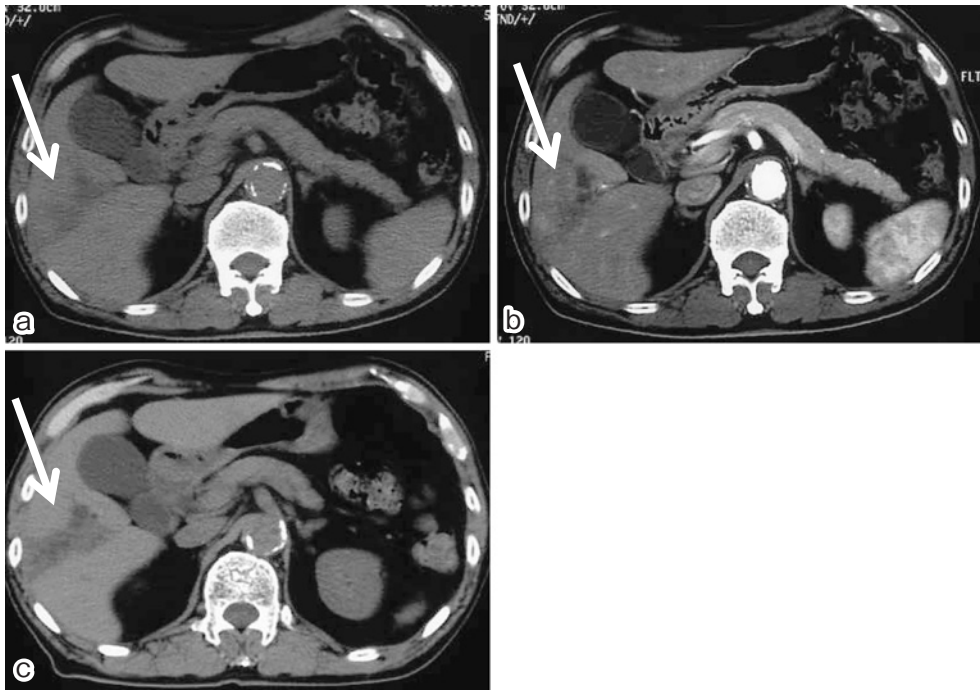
Computed tomography (CT) showed a low-density area (arrow) (a) and, after injection of contrast medium, moderately dense area in the arterial phase in segment 5 (arrow) (b). Three weeks after discharge, the patient was readmitted, and CT showed an enlarged low-density area in segment 5 (arrow) (c).
